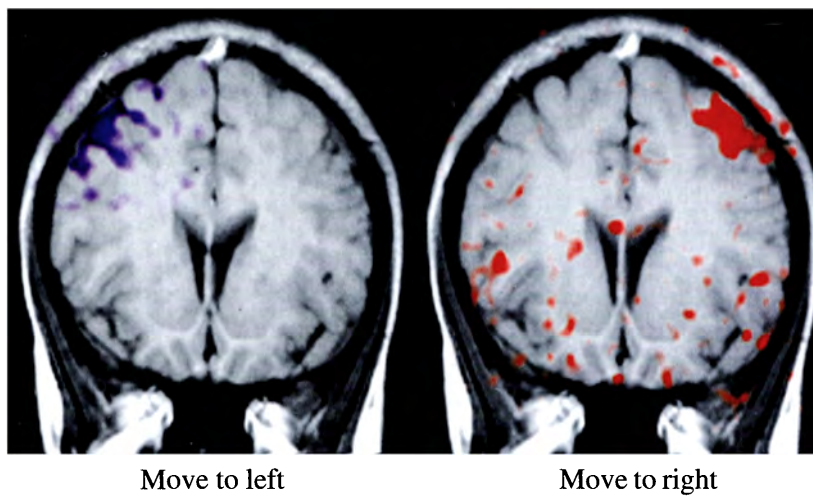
Functional MRI showing activation of motor cortex on hand movement.
